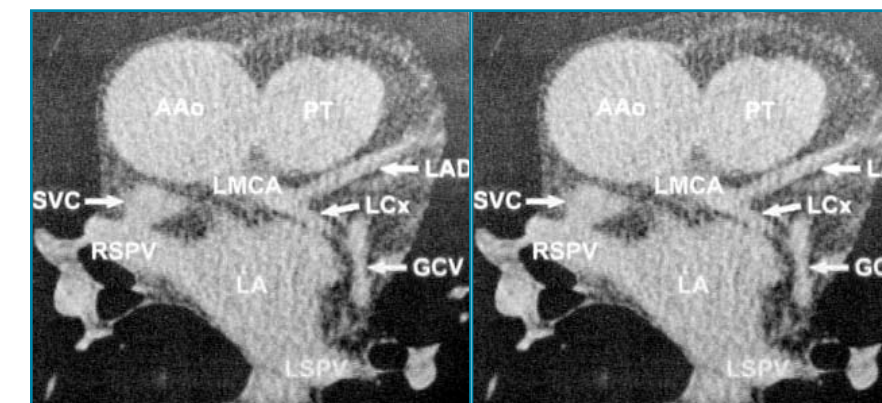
Image of the coronary arteries on a noncontrast CT scan. There is no significant coronary artery calcification. LMCA (left main coronary artery), LAD (left anterior descending artery, LCx (left circumflex coronary artery)⁴
